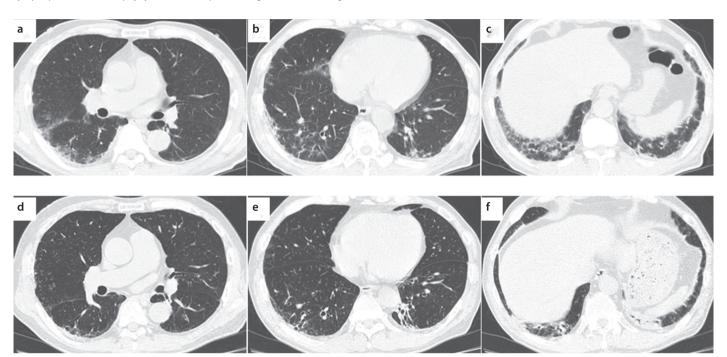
a-f. Diffuse ground-glass opacity was apparent in both lung fields (a-c) in CT images of the patient's lung. The reduction of ground-glass opacity after combination treatment was revealed (d-f)
